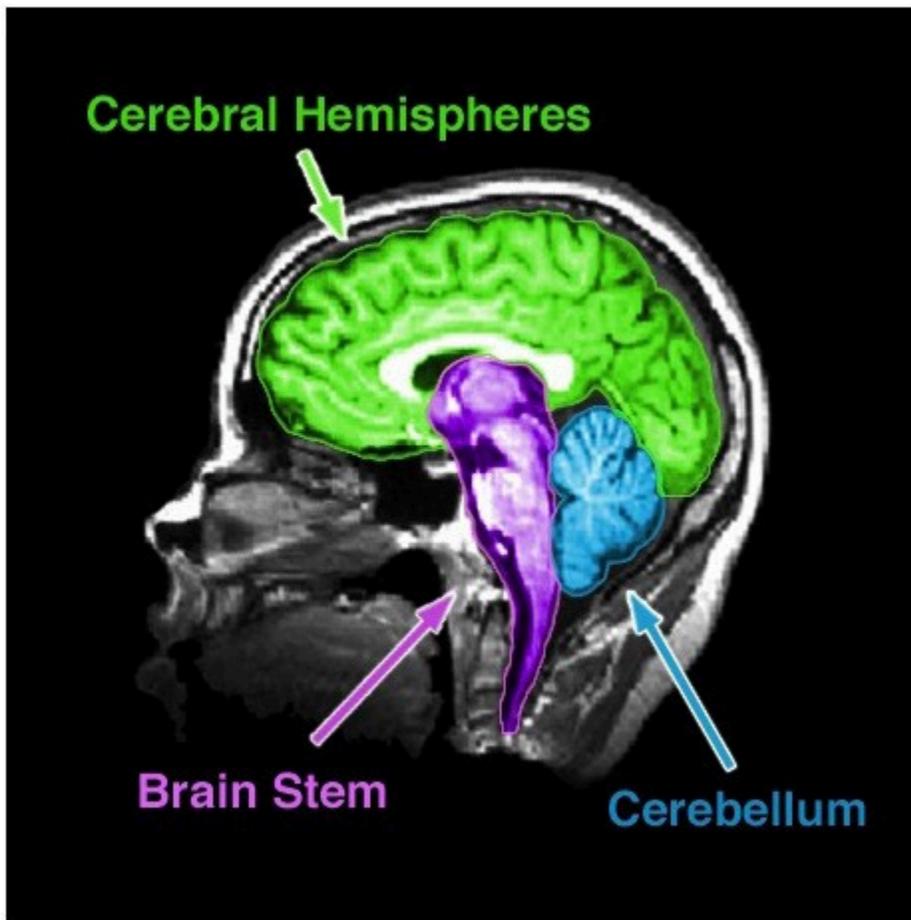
An MRI of the human brain delineating three major structures: the cerebral hemispheres, brain stem, and cerebellum.
